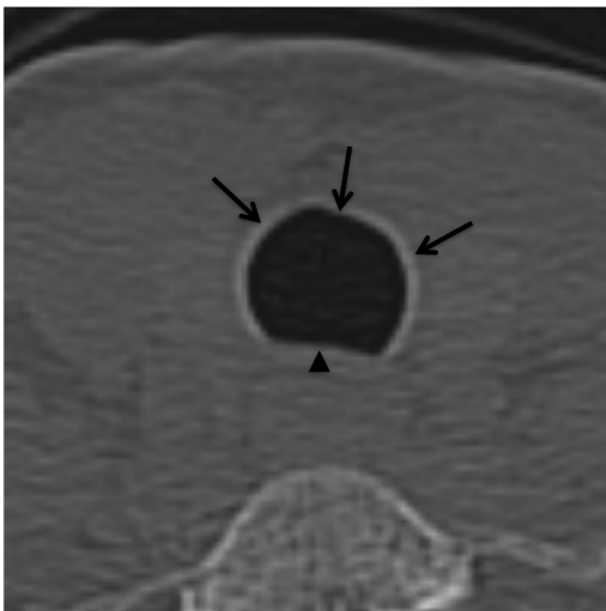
Normal tracheal anatomy on computed tomography. Axial computed tomography image of the trachea with bone windows demonstrates the anterior cartilaginous ring (arrows) as well as the membranous posterior wall of the trachea where the trachealis muscle is located (arrowhead).
